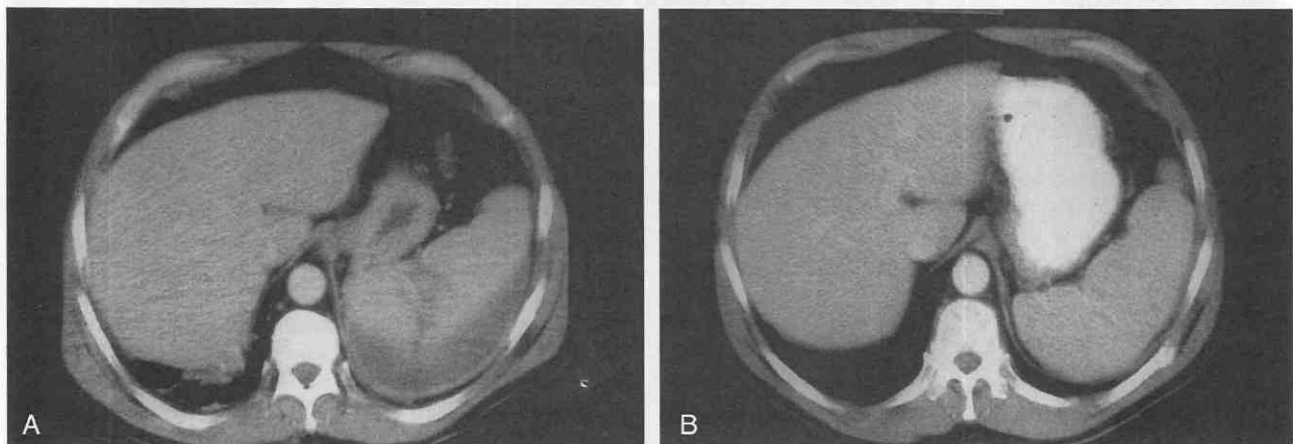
CT scans following the conservative management of a grade III splenic injury in an adult. *A*, Initial CT scan demonstrates a grade III injury with a large subcapsular hematoma and a 5-cm laceration. *B*, Follow-up CT obtained at 3 months shows complete healing.
